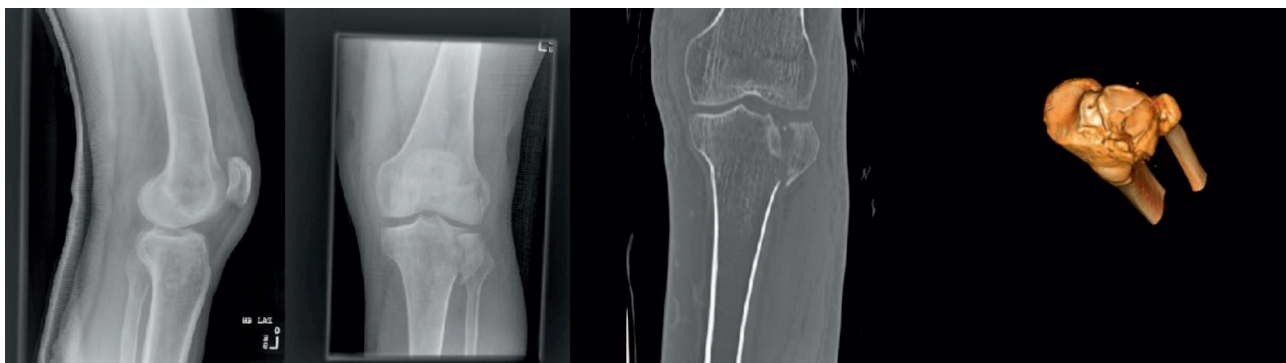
Pre-operative X-ray and CT images of injury with 3-D reconstruction
